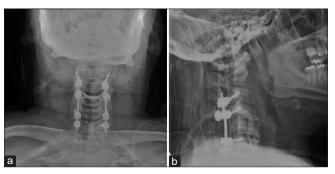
(a) Postoperative C3-C7 fusionanterior-posterior X-ray of the cervical spine. (b) Postoperative C3-C7 fusion lateral X-ray of the cervical spine.
